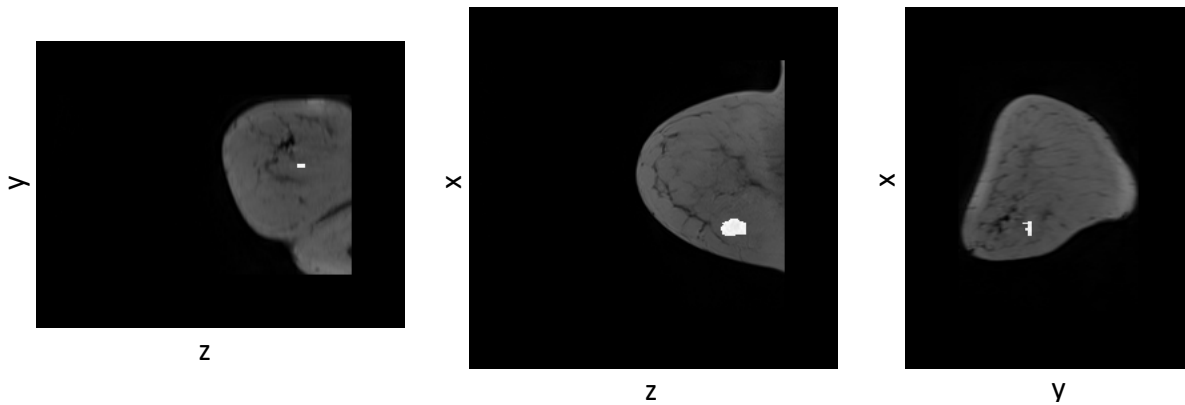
An exemplary case shows the annotated lesion by the radiologist in three views of an MR image before applying compression deformation to the breast.
